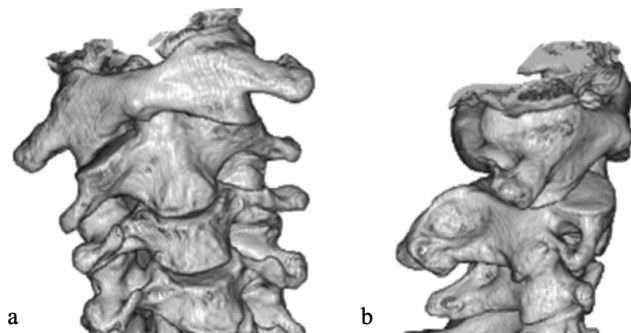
4B. Three-dimensional computed tomography of case 2 shows adult atlantoaxial rotatory fixation of Fielding type 1.
